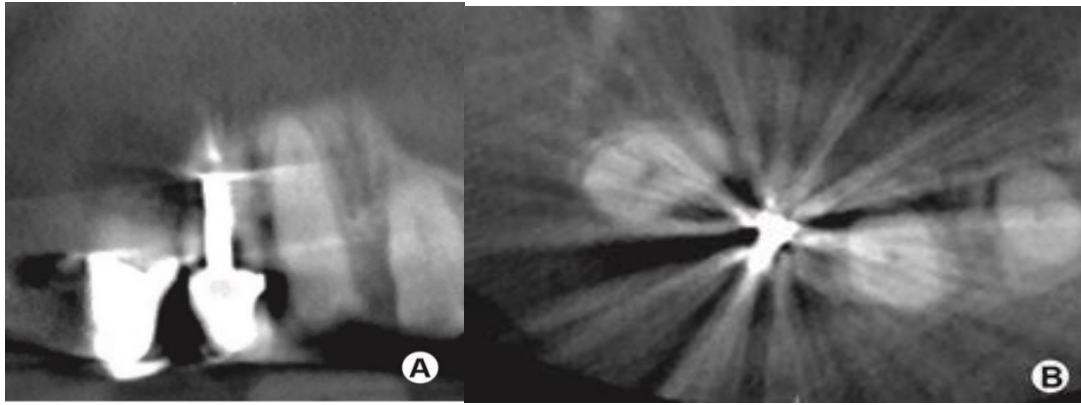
(a, b) Coronal (a) and axial (b) CBCT slices through a maxillary left central incisor tooth restored with a post-retained crown. Beam hardening caused by the metallic post has resulted in the appearance of streaks and bands, impairing the quality of the images.
